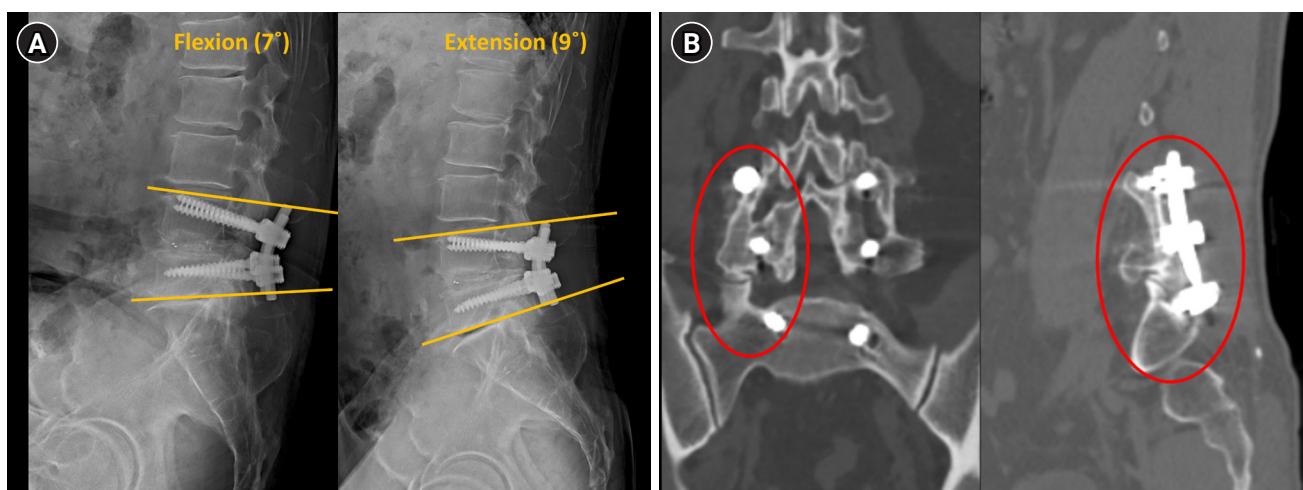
Radiologic evaluation of fusion stability. (A) Lumbar flexion (7°) and extension (9°) lateral X-ray used to assess dynamic motion between the upper and lower instrumented vertebrae. (B) Postoperative computed tomography scans showing continuous trabecular bone bridging across the fusion site (red circles), confirming solid fusion.
